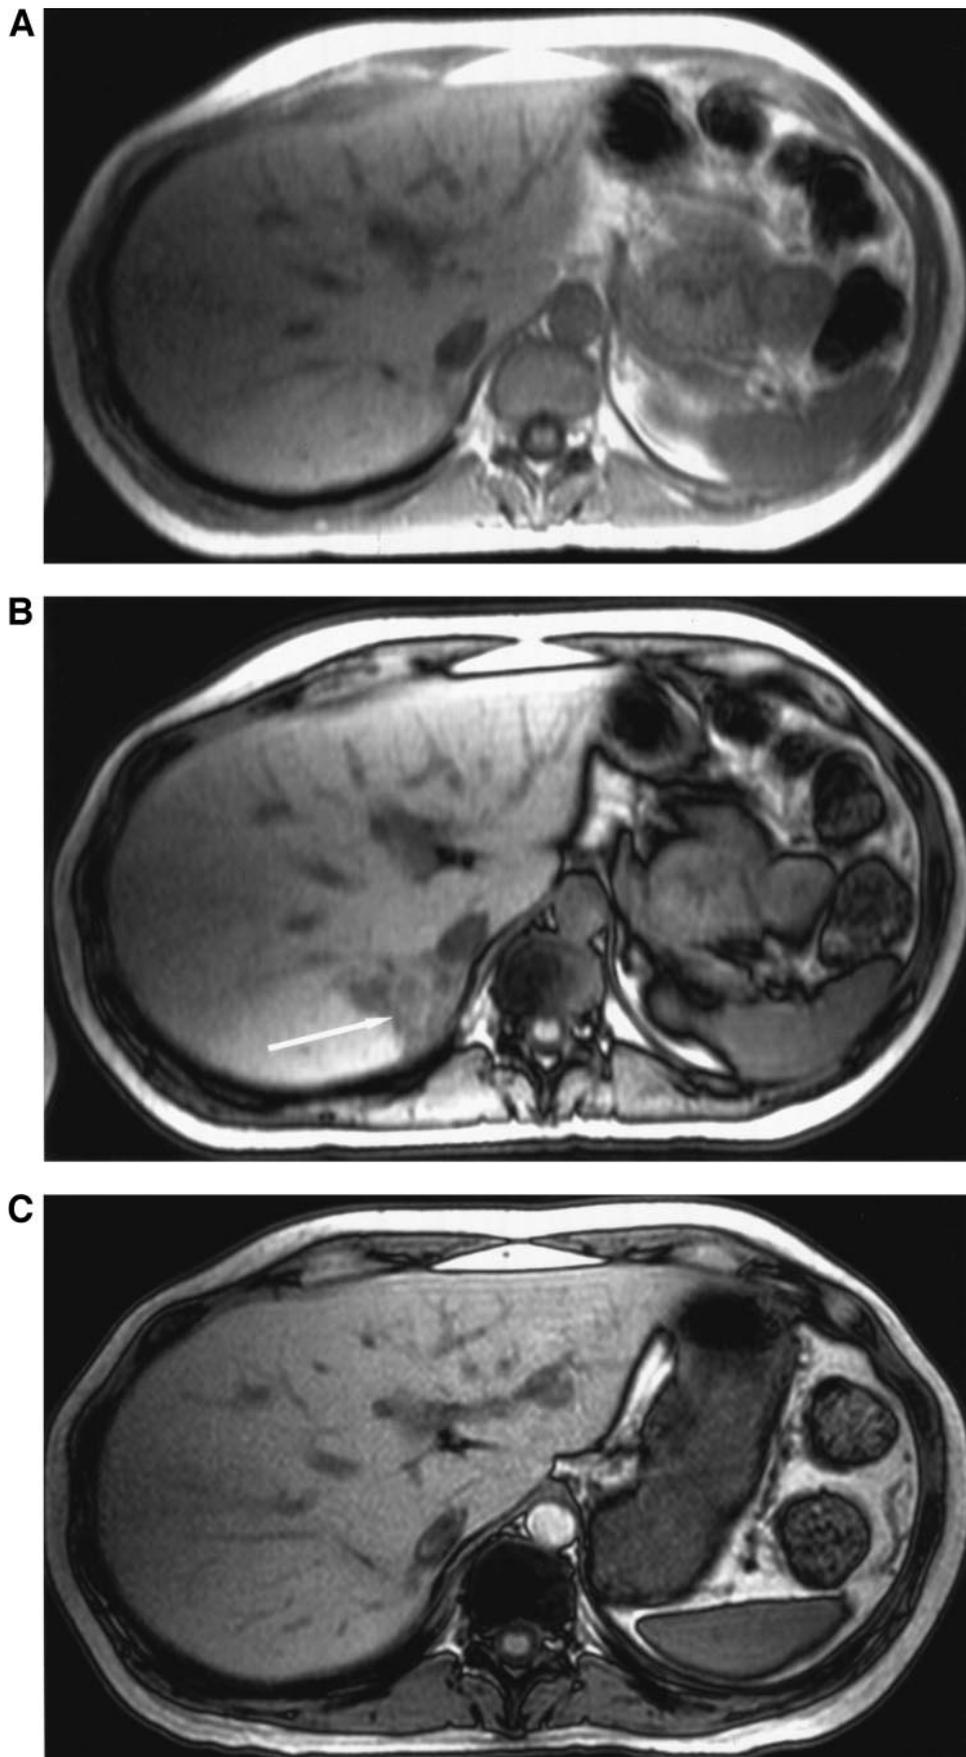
Out-of-phase T1 imaging (*B*) shows focal signal loss (*white arrow*) in the liver as compared with in-phase T1 imaging (*A*), representing focal hepatic steatosis. A follow-up MRI (*C*) at the time of islet allotransplant failure shows return of the out-of-phase T1 images to normal, indicating resolution of the steatosis.
